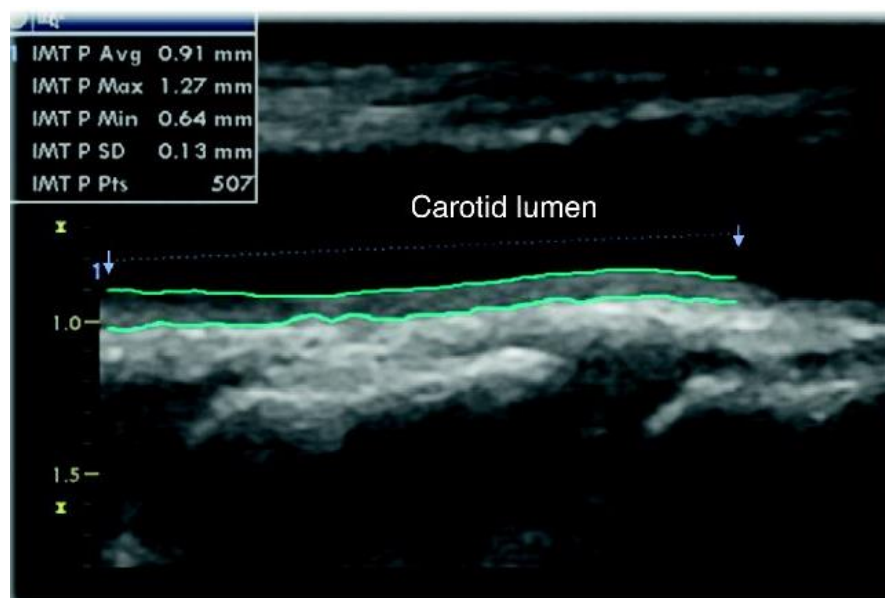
Carotid ultrasound showing a pathological increase in the mean (0.91 mm) and the maximum (1.27 mm) carotid intima-media thickness by means of automated border detection. IMT, intima-media thickness (Mateo et al. 2011).
